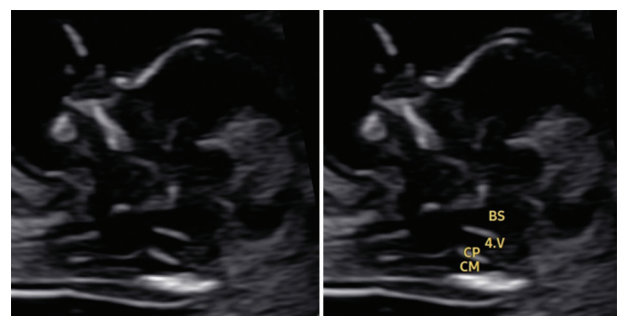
Sagittal ultrasound images of a 13-week fetus, displaying a comprehensive view of key structures within the developing brain. The left image presents an unmarked scan, while the right image includes labelled anatomical structures, such as the BS, the 4.V, the CP, and the CM, helping in the identification of critical posterior fossa components. Abbreviations: BS: Brainstem; 4.V: Fourth ventricle; CP: Choroid plexus; CM: Cisterna magna.
